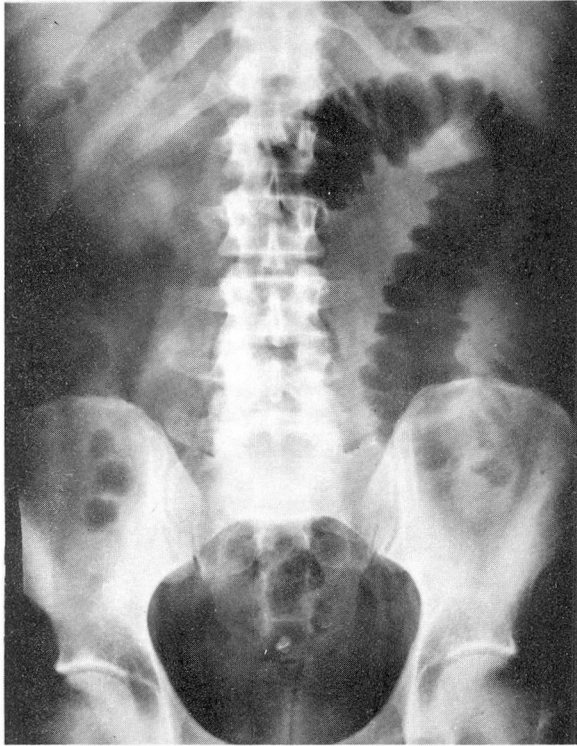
Roentgenogram of the abdomen made on October 9, 1961, showing evidence of dilated loop of small intestine.
